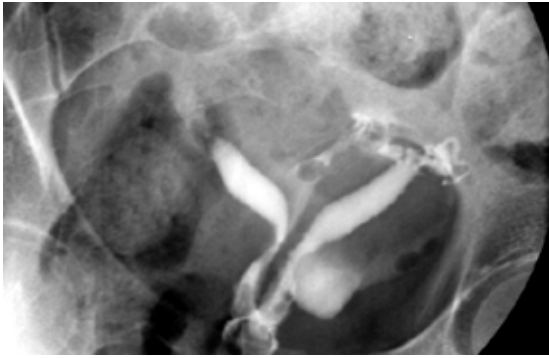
Septate uterus. Hysterosalpingogram shows a deep cleft separating the two horns of the uterus. Both septate and bicornuate uterus may have a similar appearance on hysterosalpingography. Accurate differentiation will require 3D ultrasonography or MR imaging.
